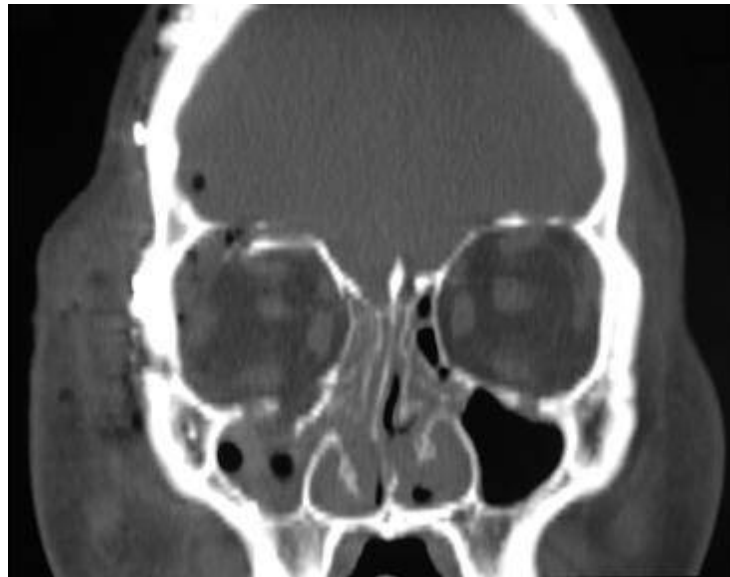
CT Scan of an orbital floor fracture. (An orbital roof fracture is also present)
